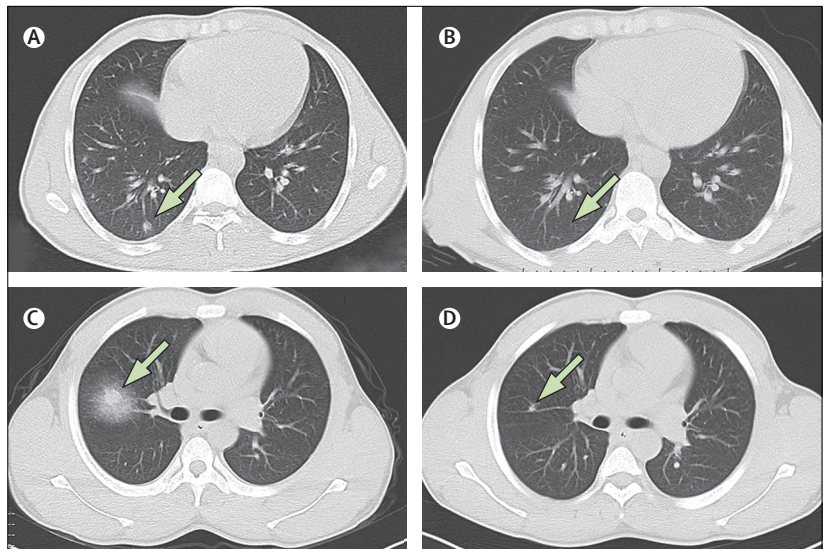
Pulmonary CT scan images
